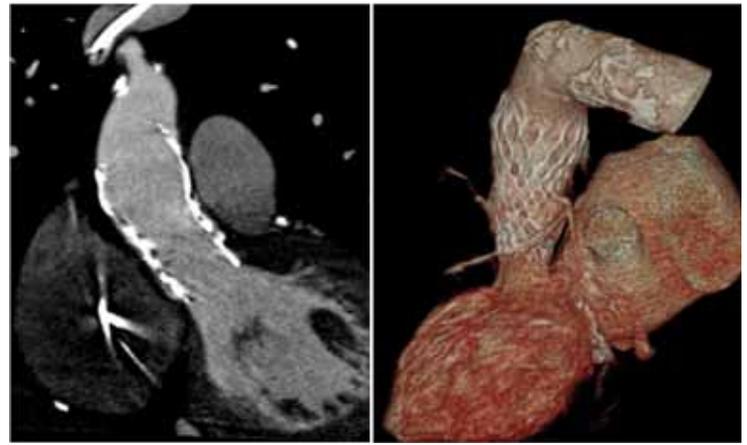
Coronal oblique CT views of aortic root (left) and three-dimensional (3D) volume-rendered image (right) of the ascending aorta in a male patient 2 weeks after transcatheter aortic valve replacement (TAVR) with a Medtronic CoreValve. The CT was performed due to the suggestion of suspected paravalvular aortic regurgitation seen on a surveillance echo. Note the adequate deployment and positioning of the prosthesis, the absence of in-stent stenosis, and the integrity of the valve stent struts.
